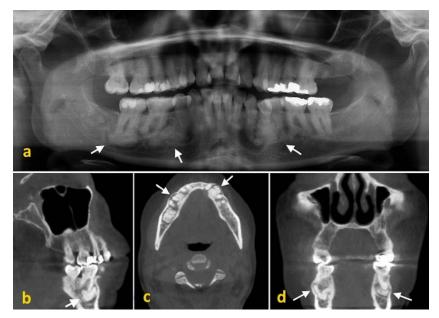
(a) The panoramic radiography of FLOD. The CBCT image of FLOD: (b) sagittal, (c) axial, and (d) coronal section showed multiple well-circumscribed opaque and radiolucent lesions associated with the roots of the mandibular teeth.
